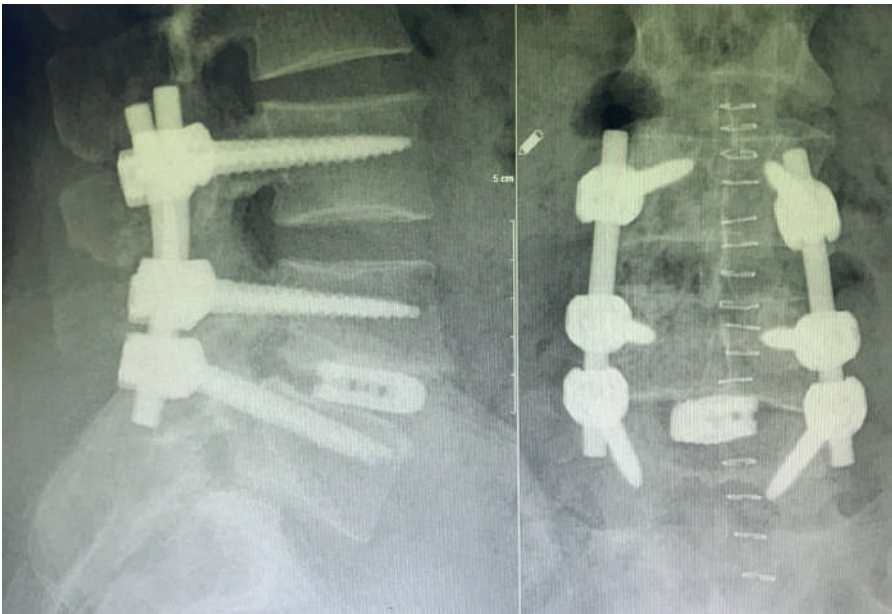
Postoperative radiographs following L5–S1 fusion for isthmic spondylolisthesis. Lateral (A) and anteroposterior (B) lumbar spine radiographs obtained after surgery in a 35-year-old male patient with L4–5 isthmic spondylolisthesis. The images demonstrate posterior pedicle screw–rod instrumentation with posterior lumbar interbody fusion (PLIF) cage placement at the L4–5 level, confirming appropriate implant positioning and restoration of segmental alignment.
